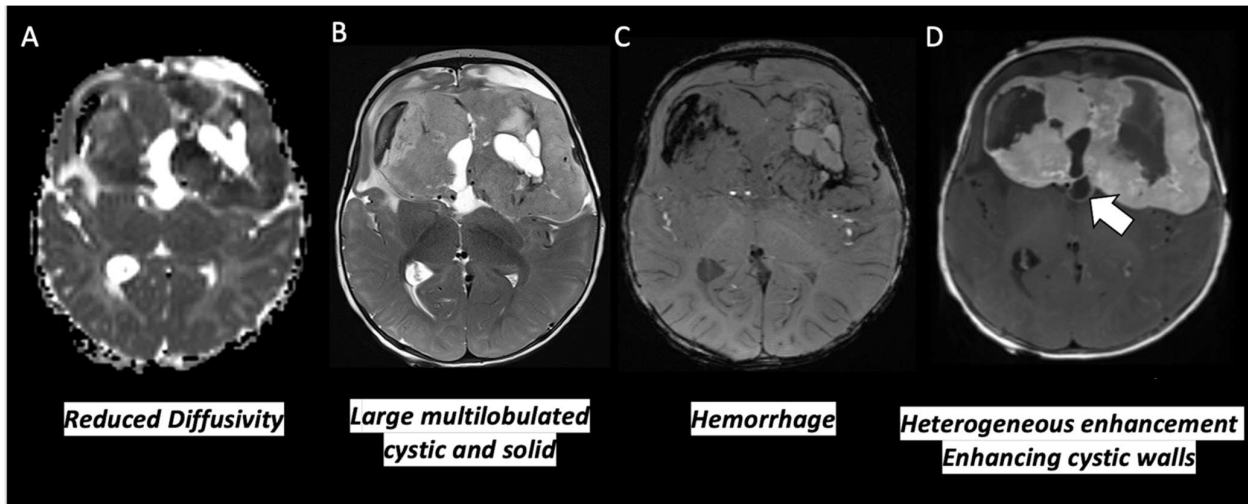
9 months old with Infantile hemispheric glioma, *RTK1* fusion positive. ADC map, T2-weighted, SWI, and T1-weighted post contrast axial images of the brain show a large solid and cystic bi-frontal mass with strong decreased diffusivity compared to adjacent cortex, hemorrhage, and enhancement. Note the enhancing cystic walls (white arrow).
